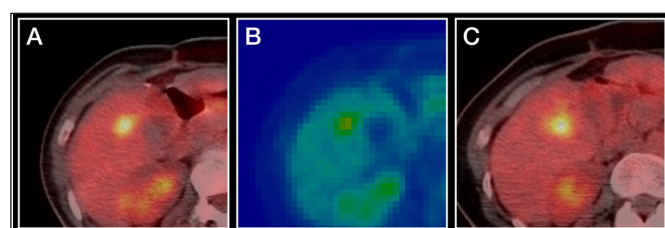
Example of a homogeneous lesion that was not responsive to TARE (A) Pre-treatment PET/CT; SUVmax: 7.34, Entropy: 5.75, Kurtosis: 5.78 (B) Textural representation of the tumor (C) Post-treatment PET/CT.
